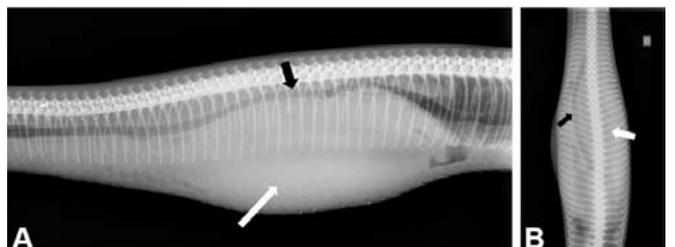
Radiographs of the cranial third of the male Burmese python (*P. m. bivittatus*) body. a) Lateral projection radiography showing an increase in soft tissue opacity superimposed over the cardiac silhouette (white arrow) and dorsal displacement of the trachea (black arrow). Cranial end is to the left. b) Ventrodorsal projection. Note again the soft tissue opacity over cardiac silhouette (white arrow) and lateral displacement of the trachea (black arrow).
